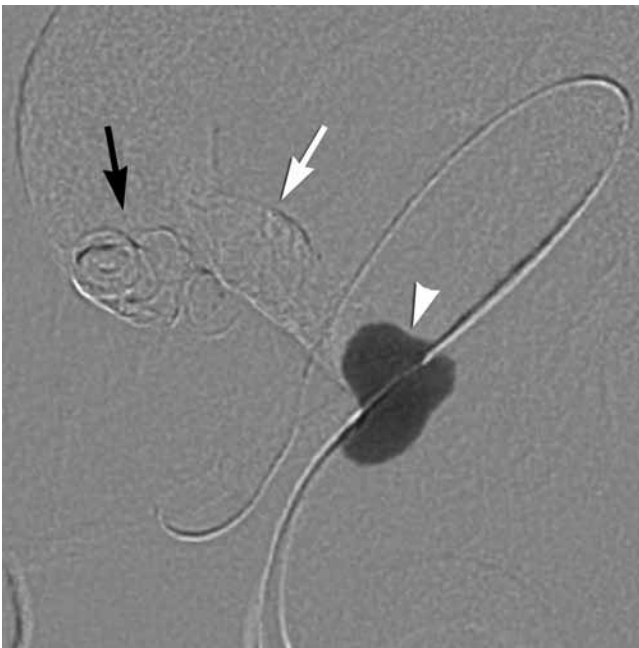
Case 2. Subtracted roadmap radiograph obtained after balloon inflation, showing the conformable balloon herniating into the feeding artery of the fistula. The Onyx cast (*white arrow*) can be seen between the portion of the balloon herniating into the vessel (*white arrowhead*) and the orphaned coil mass (*black arrow*).
